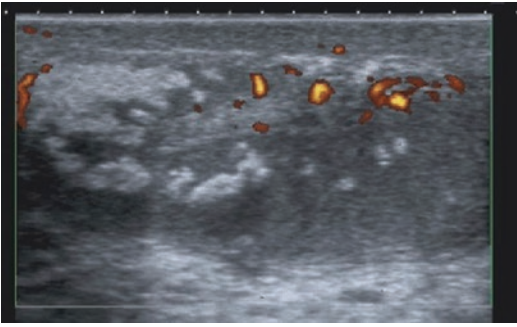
US obtained in postoperative follow-up shows focal area of survived testicular parenchyma and hyper-echoic foci of fibrosis. Power Doppler shows presence of vascular flow only in small part of tissue
